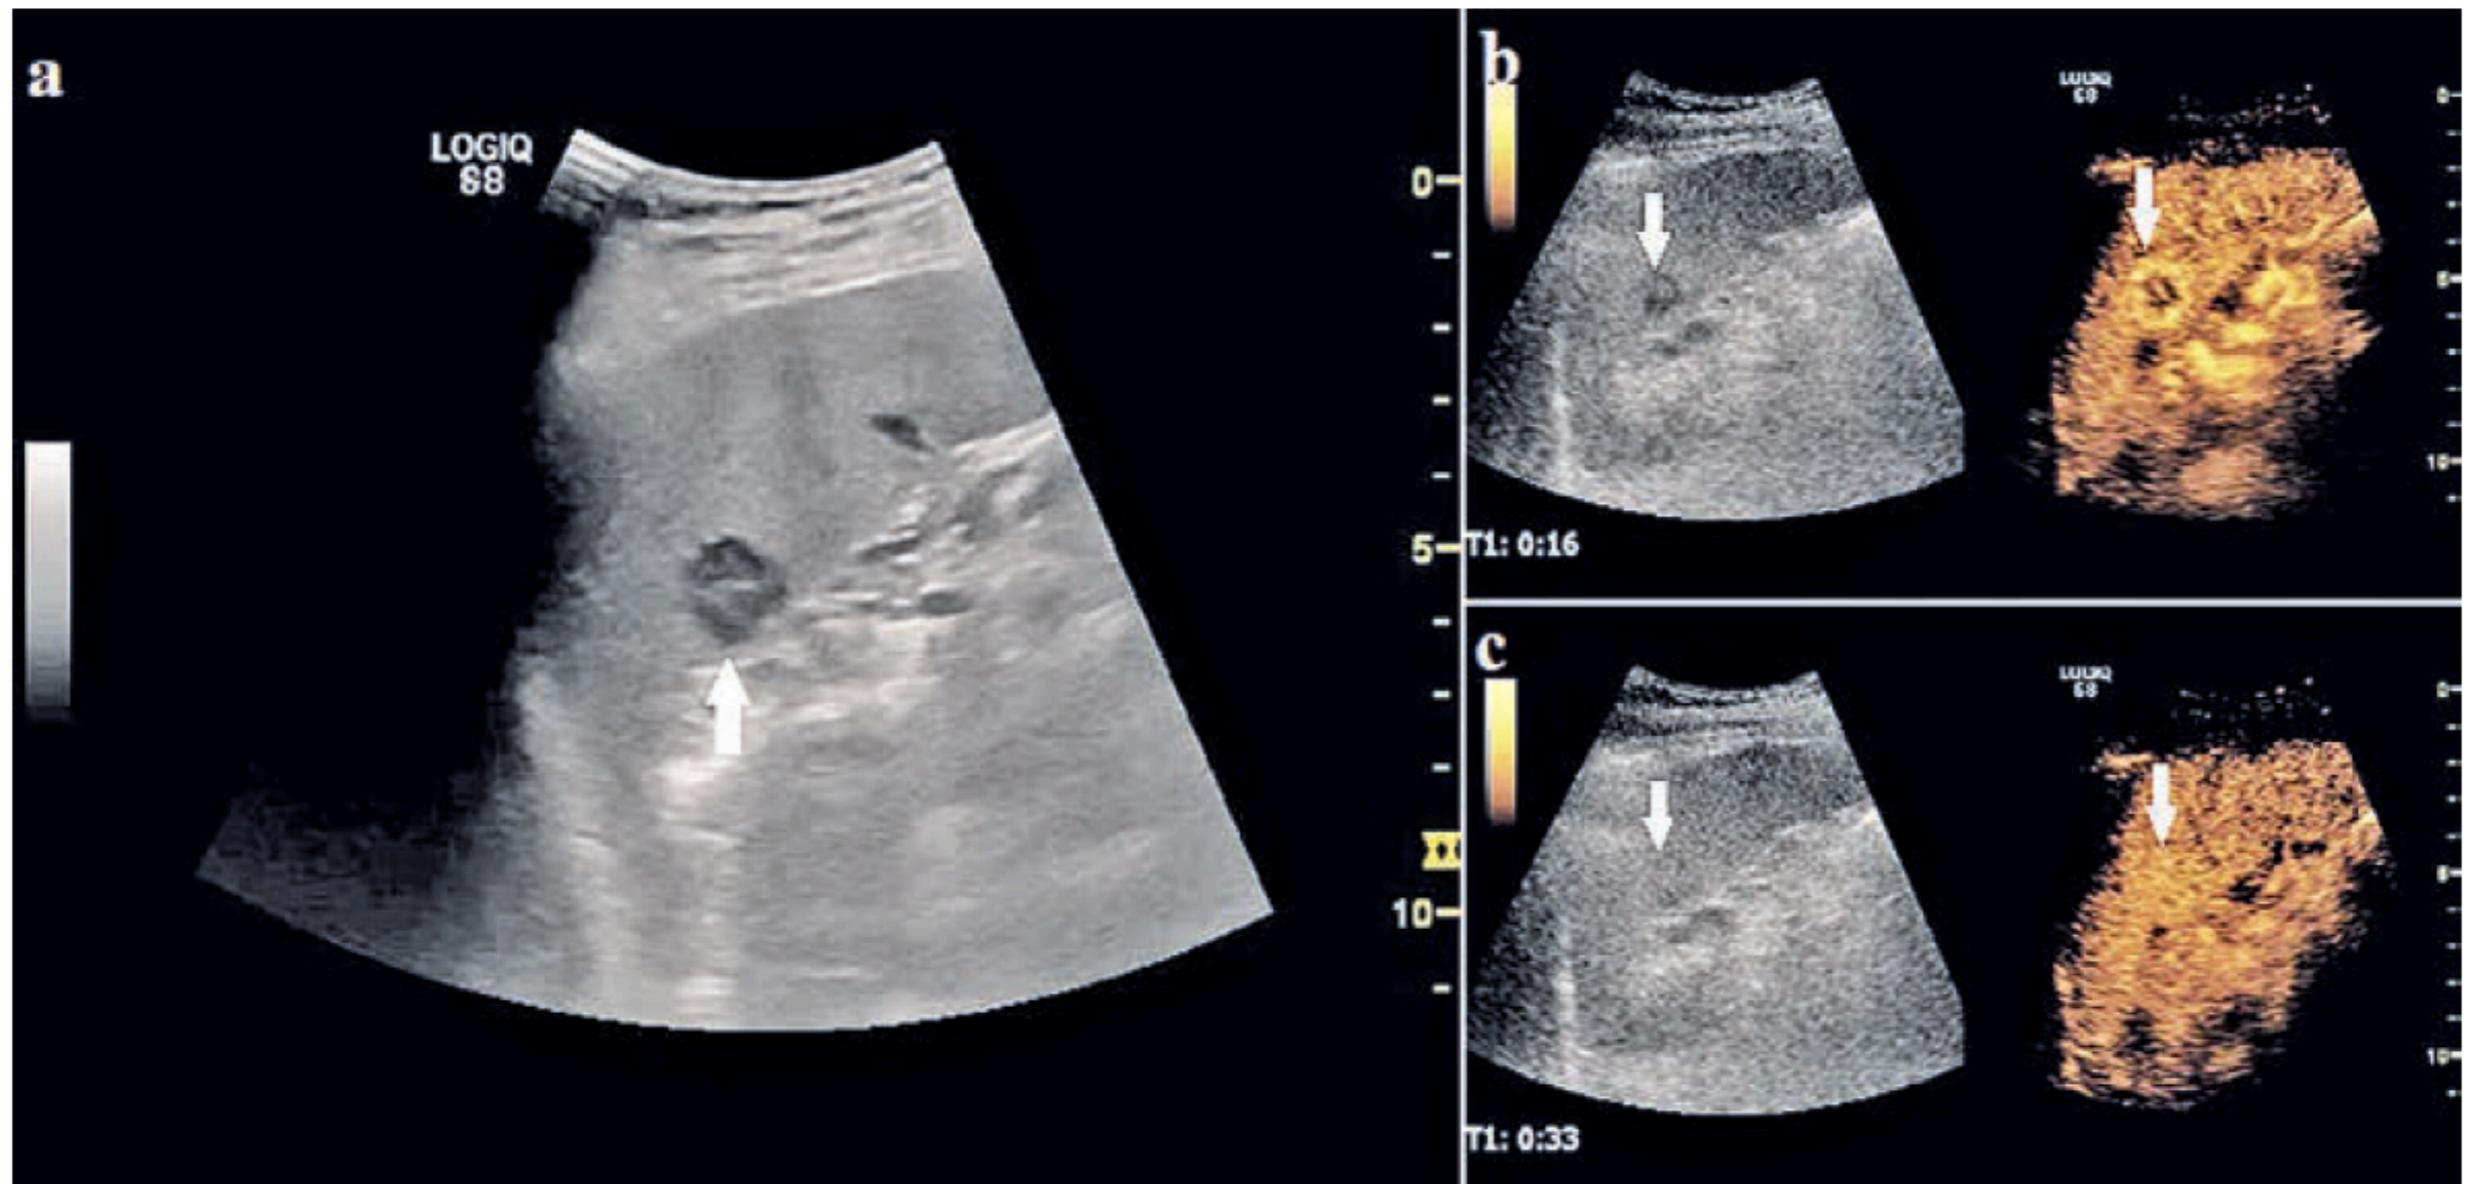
Splenic hemangioma (asterisk). a) Splenic sonography shows a hypoechoic splenic lesion in an asymptomatic patient; b,c) the splenic lesion is iso-enhancing comparing to the adjacent splenic parenchyma.
